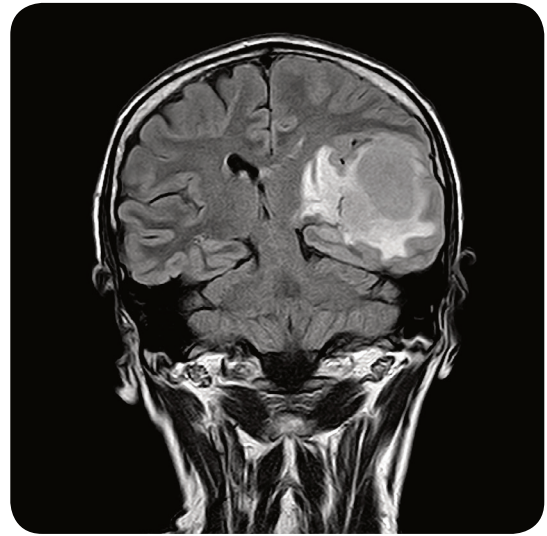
An MRI scan of the head in the coronal plane demonstrating glioblastoma of the left temporal lobe.
